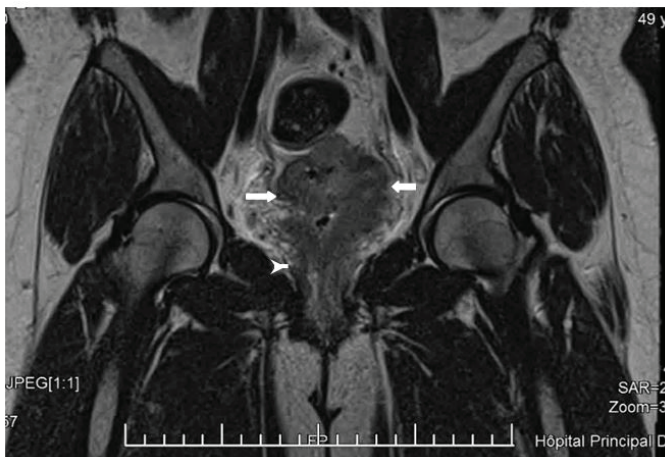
T2-weighted Coronal Section of a Cervical Tumour, with Extension to the Right Parameter (Solid Arrow) and Right Iliac Lymph Node Flow (Arrow Heads)
